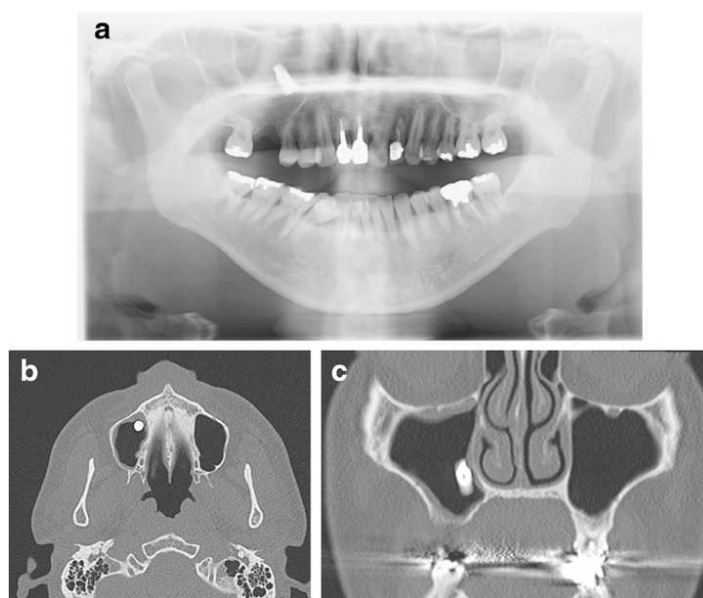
(a) Panoramic radiograph showing implant displacement into the maxillary sinus; (b) axial CT scan and (c) coronal CT scan obtained preoperatively. Adapted from Nogami et al., 2016. Reproduced under Creative Commons license (CC BY 4.0) (58).
